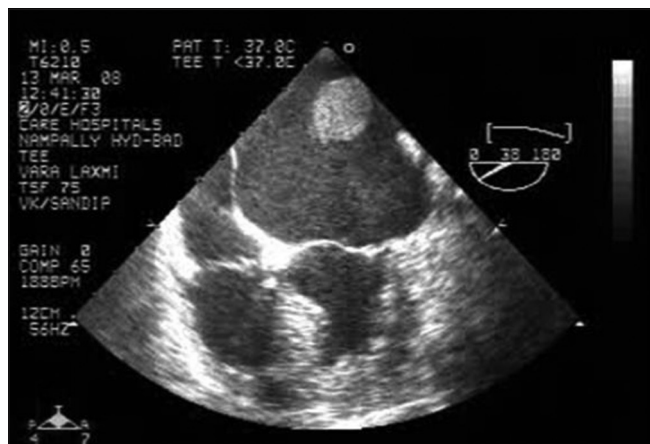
Left atrial clot seen on transoesophageal echocardiography
